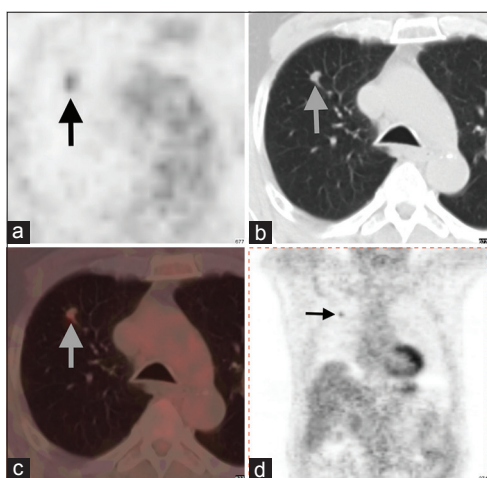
A slightly hypermetabolic nodule in the right lung (arrows) on positron emission tomography/computed tomography (PET/CT) with axial PET (a), CT (b) and fusion (c), and coronal PET (d) slices
